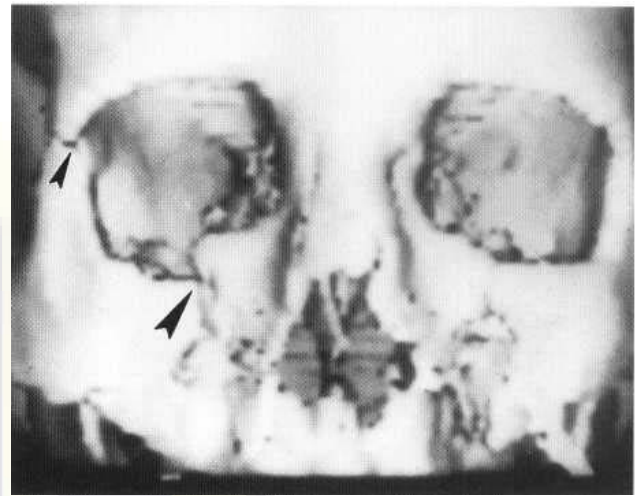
Zygomatic inferior orbital rim fracture: 3D CT. The zygomatic arch and inferior orbital rim are depressed on the right, with a comminuted fracture involving the inferior orbital rim (large arrowhead) and frontozygomatic suture (small arrowhead).
